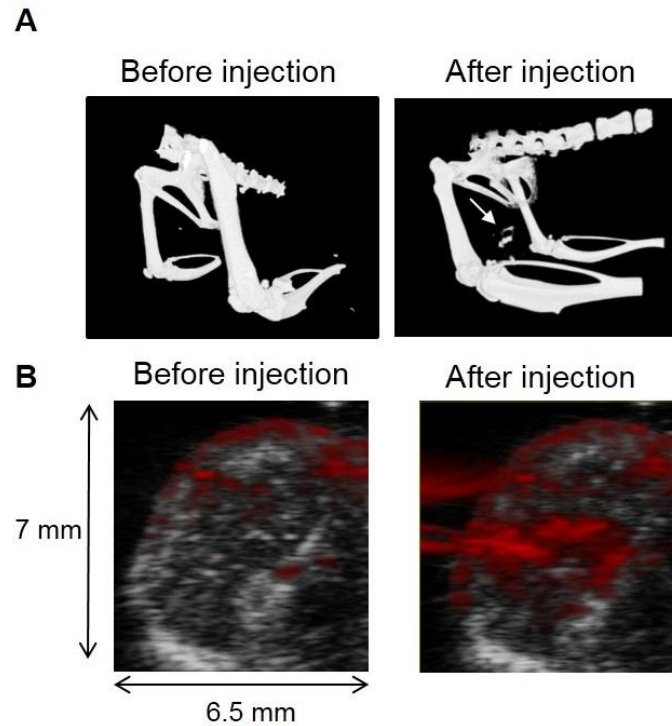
A. CT images before and after injection of nanostars into the tumor. An increased contrast is noticed at the tumor site after gold nanostars injection (arrow) B. *In vivo* PA images before and 24 h after nanostar injection. The PAI signal (red pixels) is overlaid over the anatomical ultrasound images (grey pixels).
